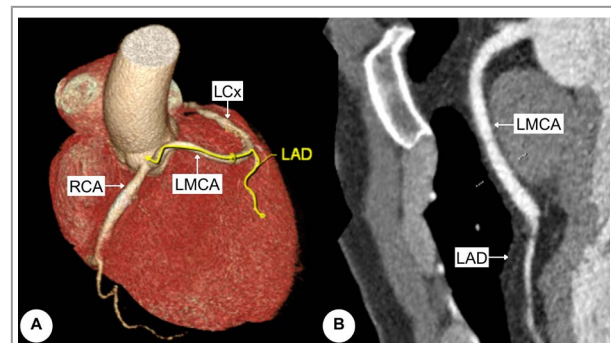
Coronary computed tomography angiography with reconstructed views (LMCA and LAD course is highlighted in yellow).
